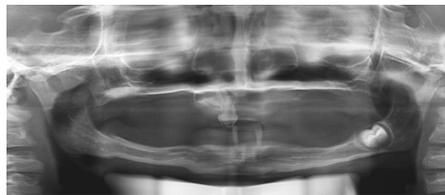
radiograph of case 3 showing deficient alveolar height of both maxillary and mandibular jaws.
